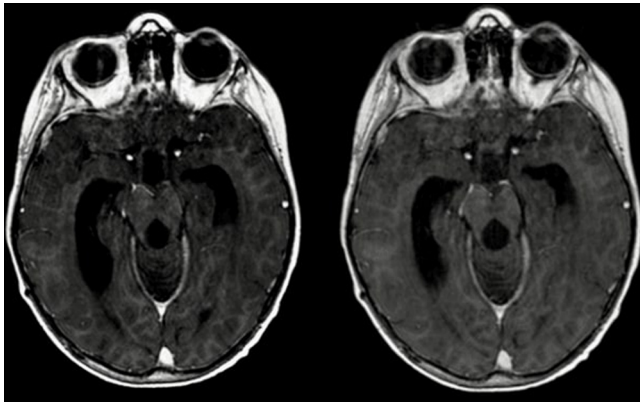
Preoperative magnetic resonance imaging scans—axial view.
